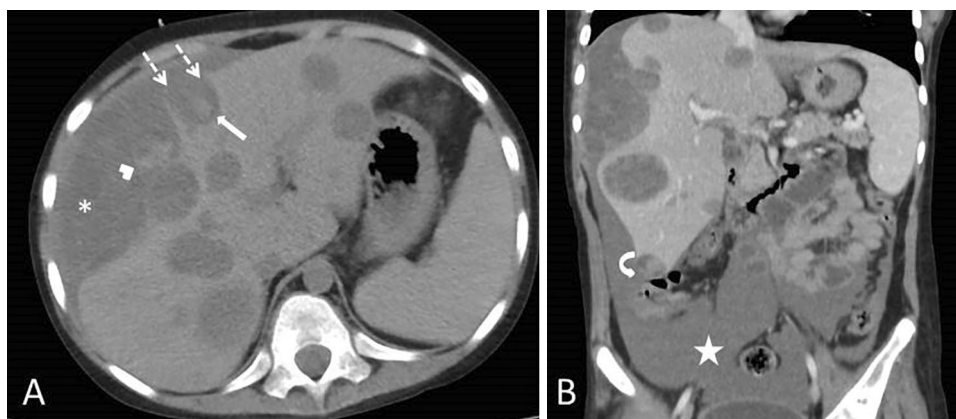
30-year-old female patient with known synovial sarcoma presenting with acute abdominal pain. A Axial precontrast CT image shows multiple liver metastases. Focal discontinuity of the capsule (dashed arrows) around a subcapsular metastasis (arrow) and subcapsular liver hematoma (asterisk) with retracted clot (arrowhead)
